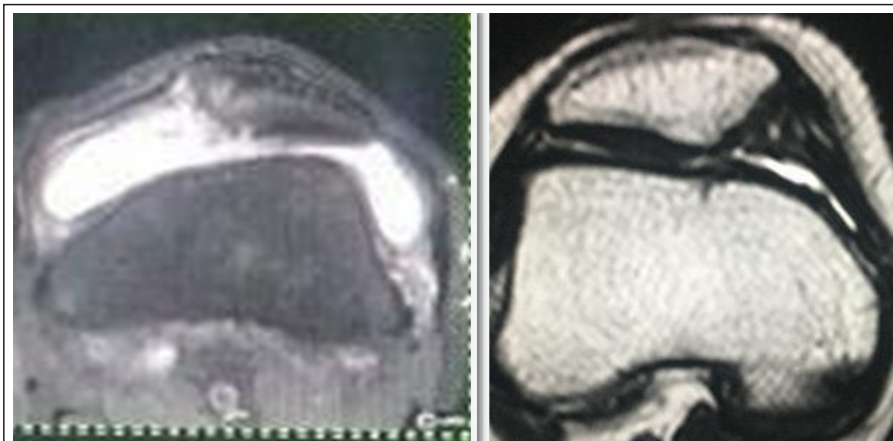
(a) Post-operative MRI showing complete healing of osteochondral fracture with regeneration of MPFL. (b) Post-operative MRI showing complete healing of chondral fracture with complete regeneration of MPFL.
